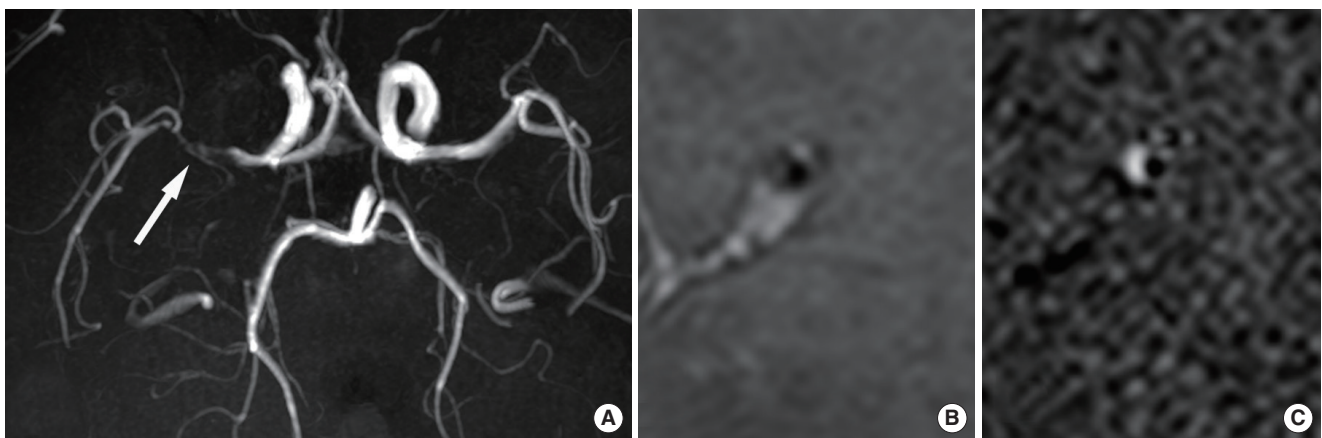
Intracranial atherosclerosis. A 49-year-old female patient presented with left-side weakness and four atherosclerotic risk factors. (A) Time-of-flight magnetic resonance angiograph showing severe stenosis in the right middle cerebral artery (arrow). (B) Proton-density image showing eccentric wall thickening and atherosclerotic plaques with a remodeling index of 1.47. (C) Contrast-enhanced T1-weighted image showing strong enhancement in eccentric atherosclerotic plaques.
